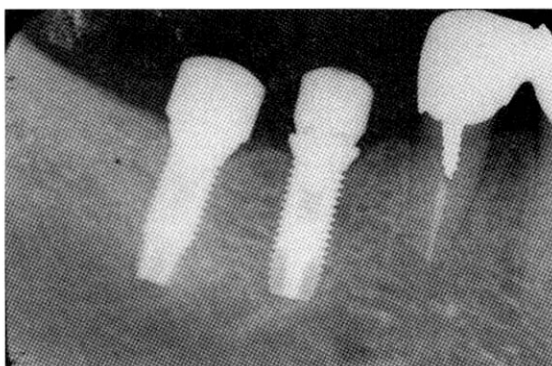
Periapical x-ray taken after 3 months healing period
